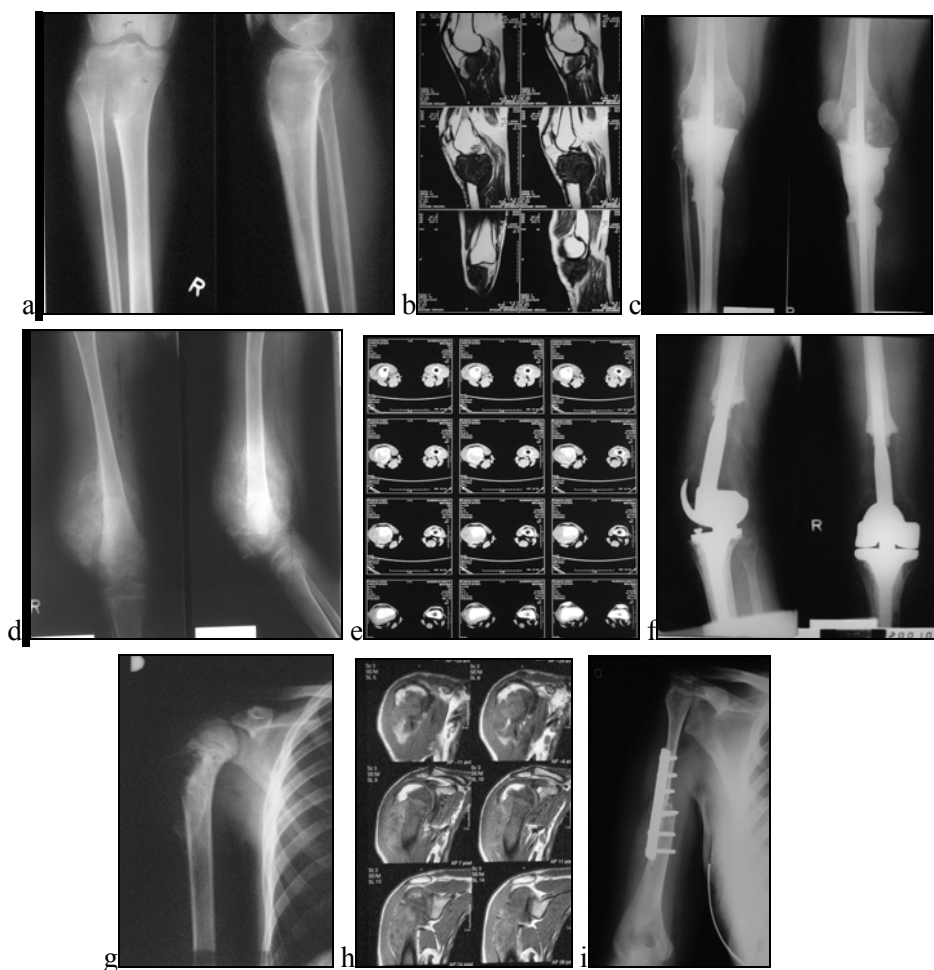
Various surgical options for limb-sparing: a, b, c x-rays and MRI of tibial osteosarcoma treated with resection arthrodesis (temporary or first stage procedure); d, e, f x-rays and CT of osteosarcoma patient with distal femur and knee special endoprosthesis reconstruction (Link); g, h, i x-rays and MRI of proximal humerus osteosarcoma treated with vascularised cortico-spongious graft (fibula) and osteosynthesis
